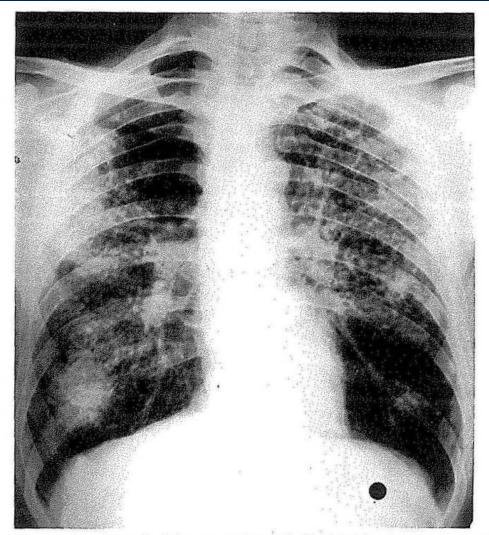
Radiograph of the same patient as in Fig. 7-3, taken in 1958. Category B complicated silicosis has developed in right upper and lower zones.
